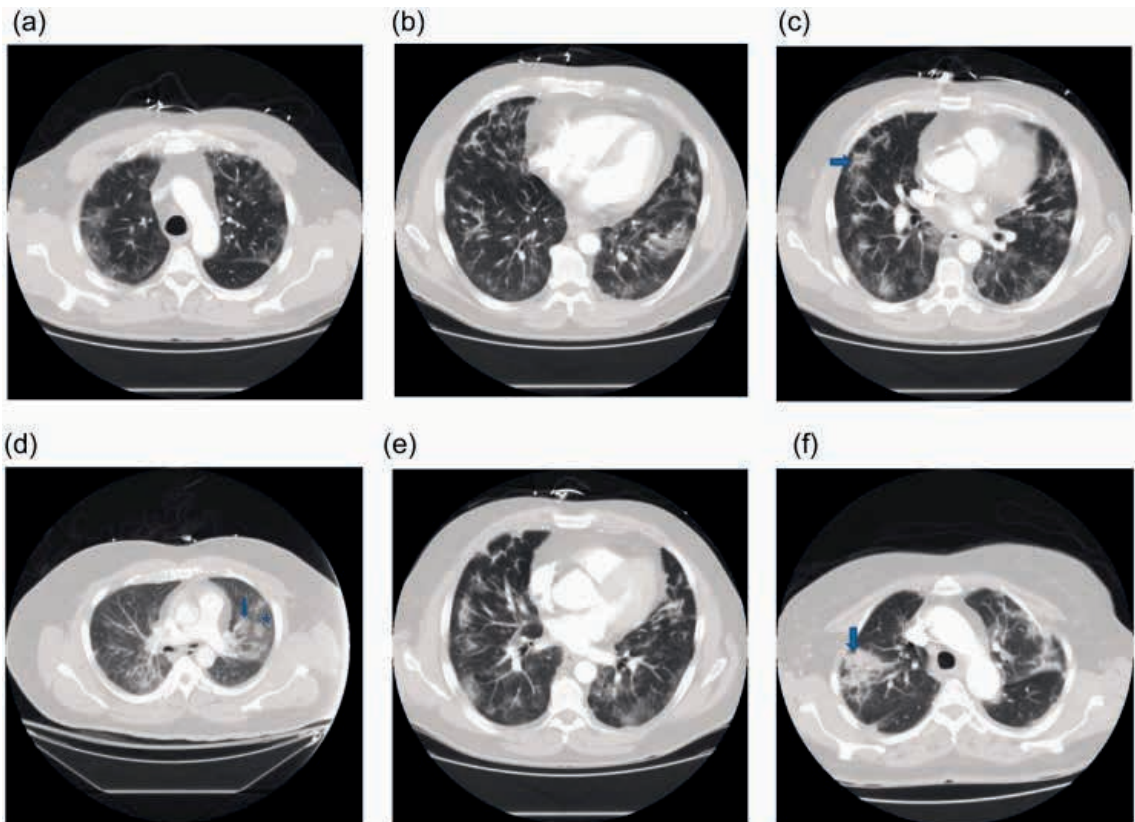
Chest CT images of patients with COVID-19, demonstrating disease progression: (a) mild alveolar infiltrates, (b) linear opacities, (c) reverse halo sign (blue arrow), (d) consolidation (blue arrow), (e) crazy paving pattern (GGO with interstitial changes) and (f) consolidation (blue arrow).
